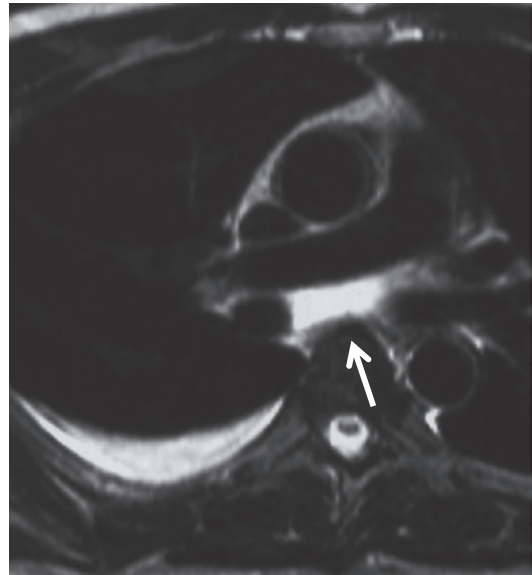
Ruptured bronchogenic cyst. The bronchogenic cyst ruptured after abrupt increase in size. T2-weighted MR image reveals a bronchogenic cyst at the carina (arrow) and right side pleural effusion
